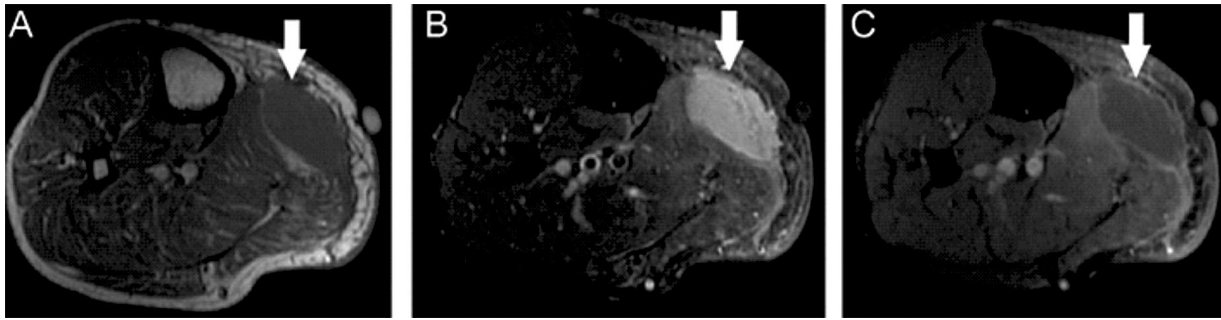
MRI of the right leg in the axial section T1-weighted sequence in A, T2 STIR in B and T1 sequence with contrast in C demonstrating a collection between the musculature and subcutaneous tissue with peripheral contrast enhancement (white arrows)
